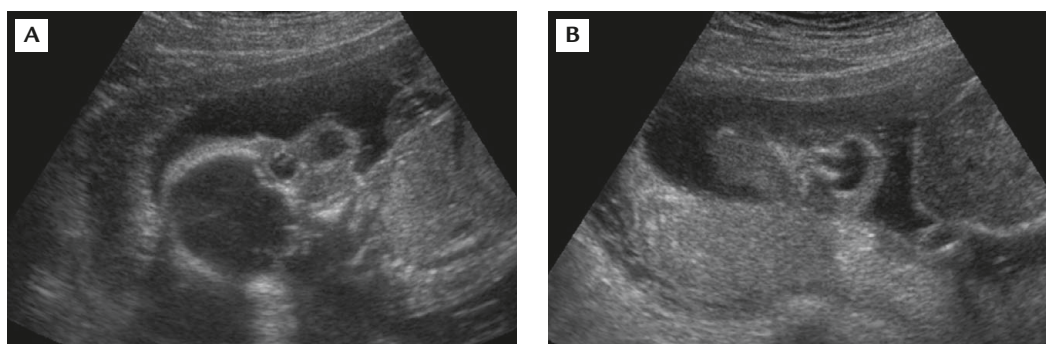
Two-dimensional ultrasound of the fetal head at 18 weeks' gestation shows alobar holoprosencephaly with fused thalami and a single ventricle.
